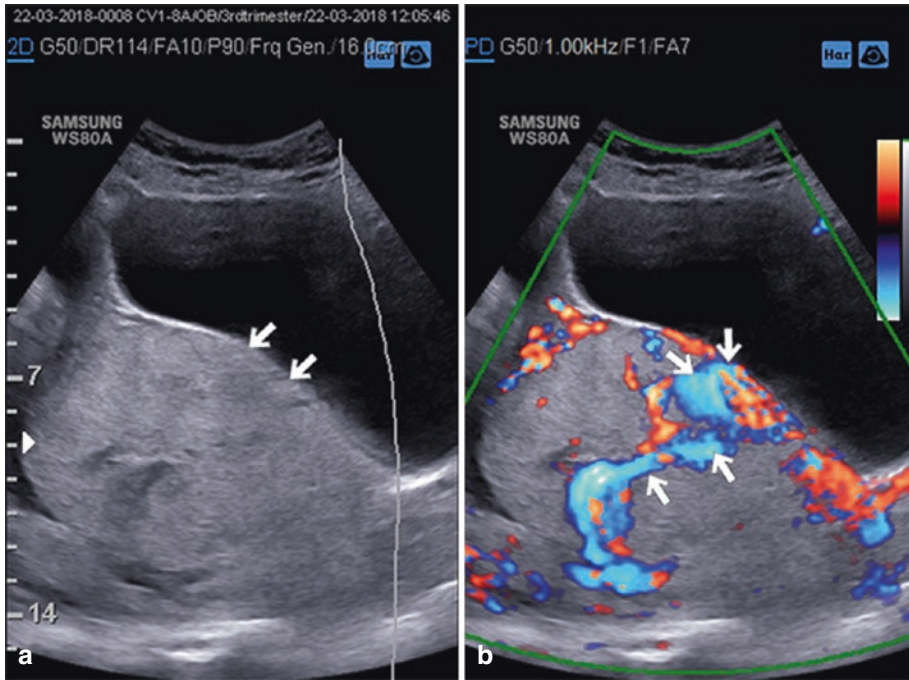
(a) Undetectable of myometrial wall (arrow) in Transabdominal 2D ultrasound and (b) bridging vessel which is appearing to extend from placenta into bladder (arrow) in 33 weeks of gestational age
